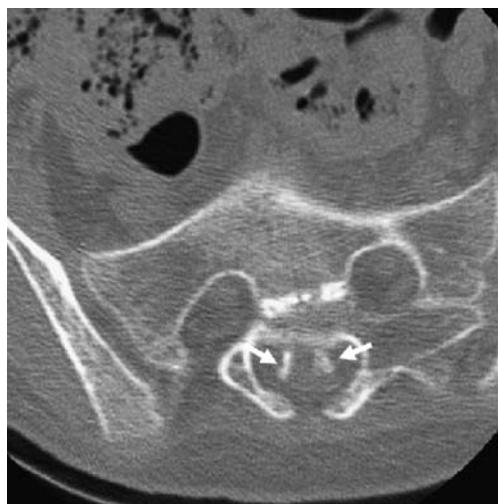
Axial non-contrast CT image of the spine
